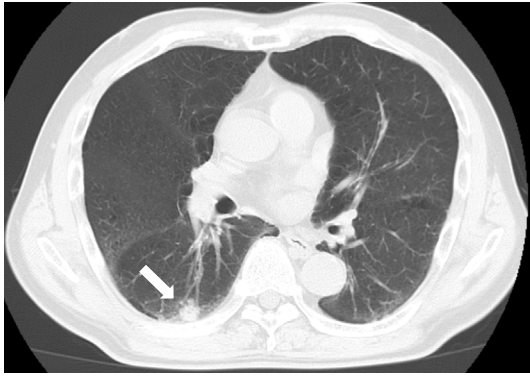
Chest computed tomography performed at the diagnosis. A nodular shadow is seen at the right lower lobe (arrow).
